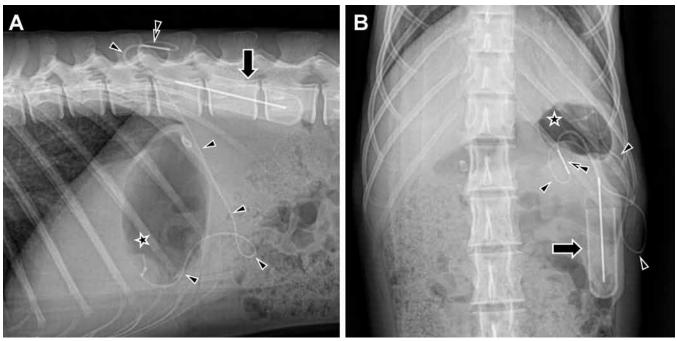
(A) Lateral and (B) ventrodorsal radiographs showing the osmotic pump (large arrow), catheter (single arrowheads), catheter repair connector (double arrowhead), and tip of the catheter in the stomach lumen (star).
